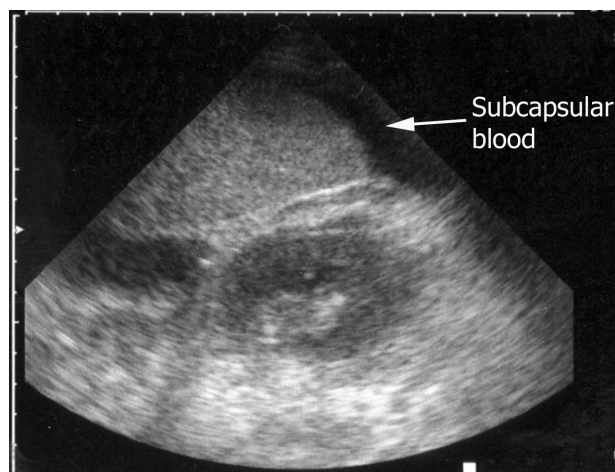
Ultrasound image of splenic subcapsular fluid.
